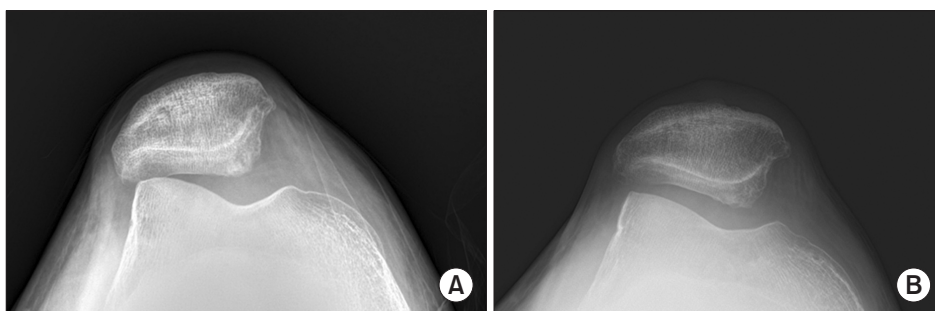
Preoperative and follow-up radiographs. (A) Preoperative Merchant view showing a subluxated patella. (B) Follow-up Merchant view showing a nondislocated patella.
